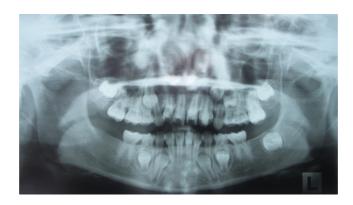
Panoramic radiograph shows a supplemental left maxillary lateral incisor and congenital absence of the maxillary first premolar, all second premolars, both mandibular first molars and the right second molar.
